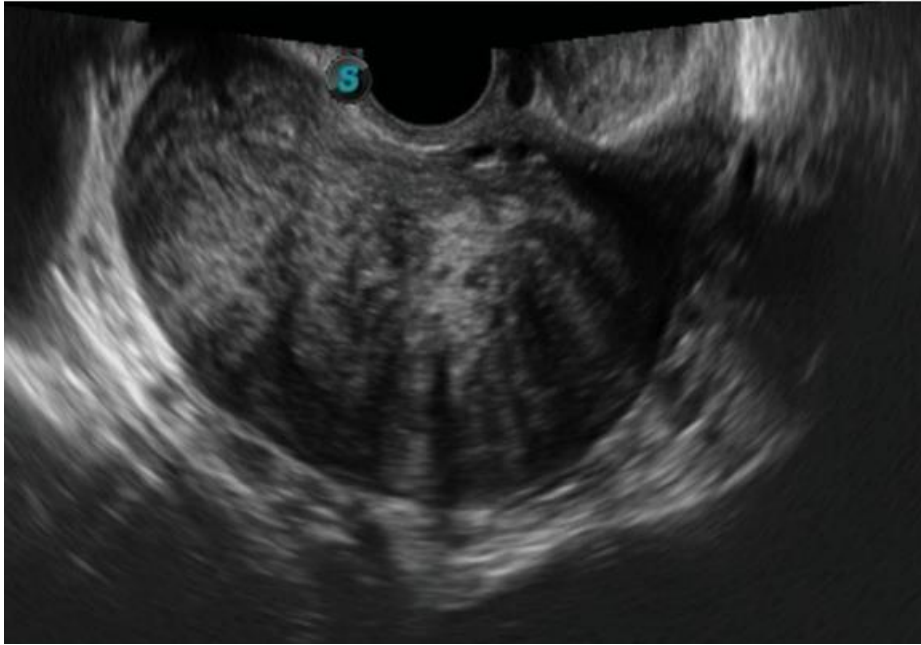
Transvaginal ultrasound (TVUS)
